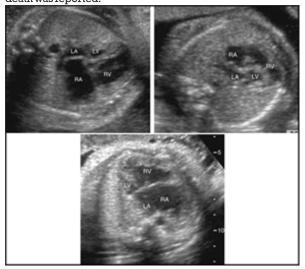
(a-c) Ultrasonography images of a fetus of 21-week 5 days gestational age shows small sized and hyperechoic left ventricle on four-chamber view of heart with no flow through mitral valve orifice.
